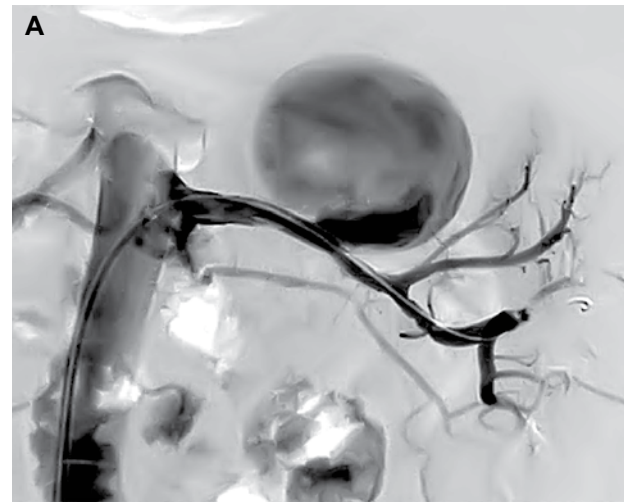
A. An angiographic check confirmed the presence of the 4.6 cm aneurysm. The vessel originating from the aneurysm in the computed tomography scan was not revealed angiographically because of the predilection of flow in the renal artery in the selective study. B. A 5 × 38 mm polytetrafluoroethylene-covered stent was advanced and deployed over the aneurysm neck, successfully excluding the aneurysm.
